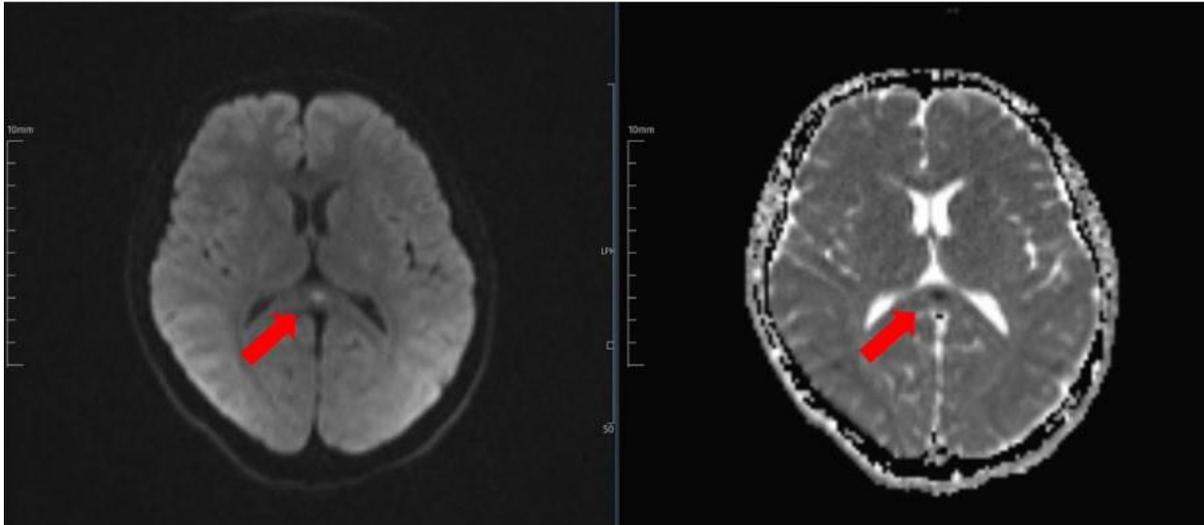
DWI MRI finding for Case 2. Hyperintensity in DAG images, hypointensity in ADC
